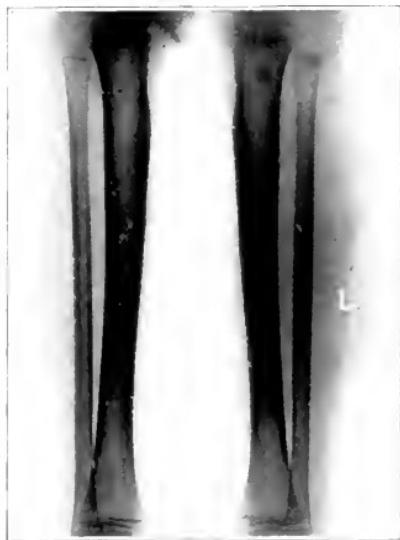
Roentgenogram of the bones of the legs in Case 14, one month after the onset of an attack of acute poliomyelitis. The bones of both legs appear normal.
